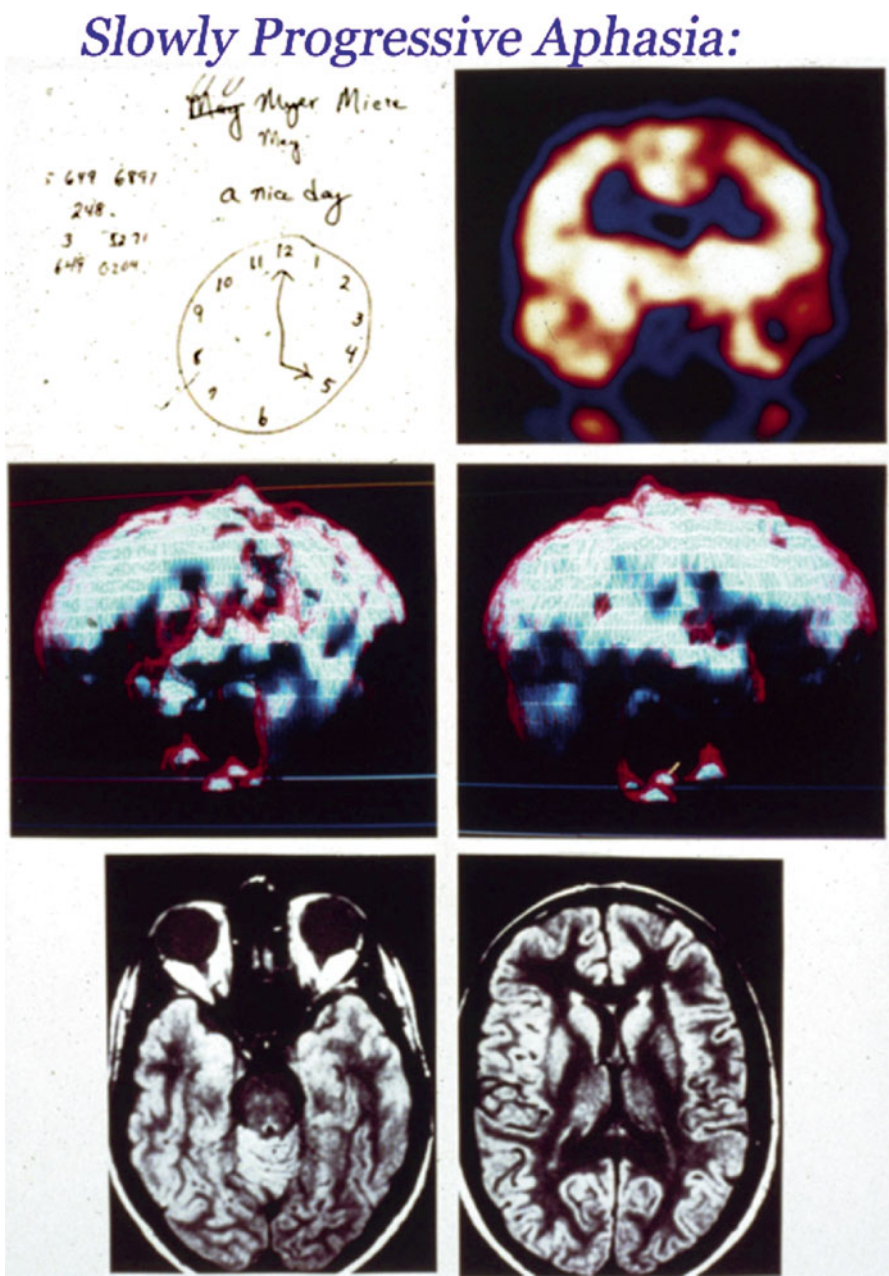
Case example: slowly progressive aphasia in a 60-year-old female who had worked as a telephone receptionist, but then had progressive difficulty with expressing herself with difficulty writing as well, referable to SPECT
